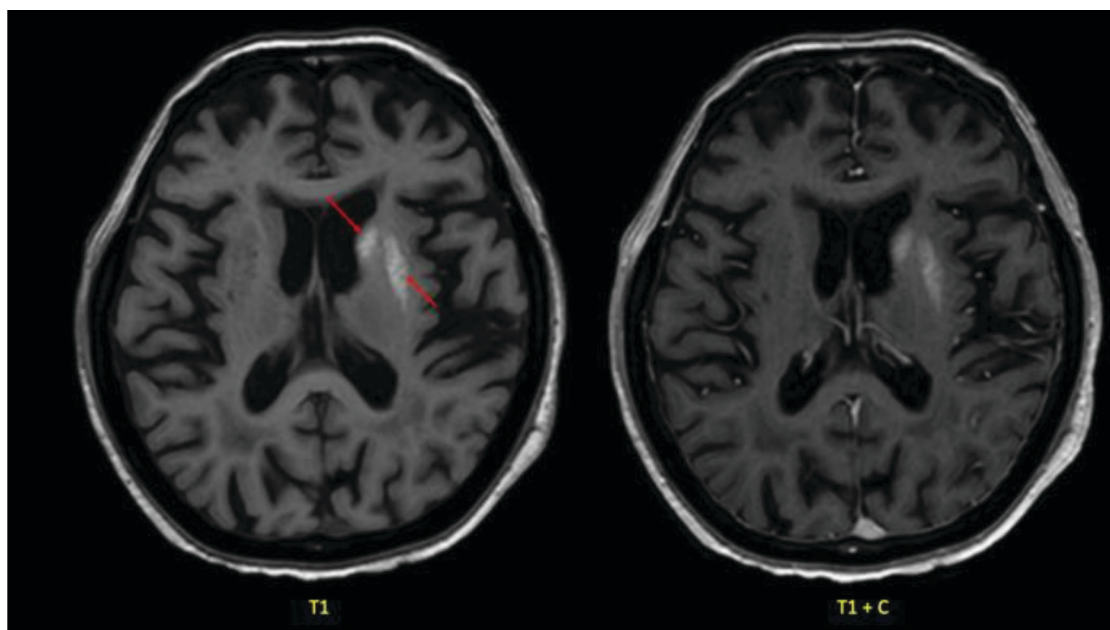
Contrast enhanced cranial MRI (T1 and T1 + C sequences on axial and coronal view), area of T1 hyperintense signal is seen at the body of the left caudate nucleus and left putamen.
